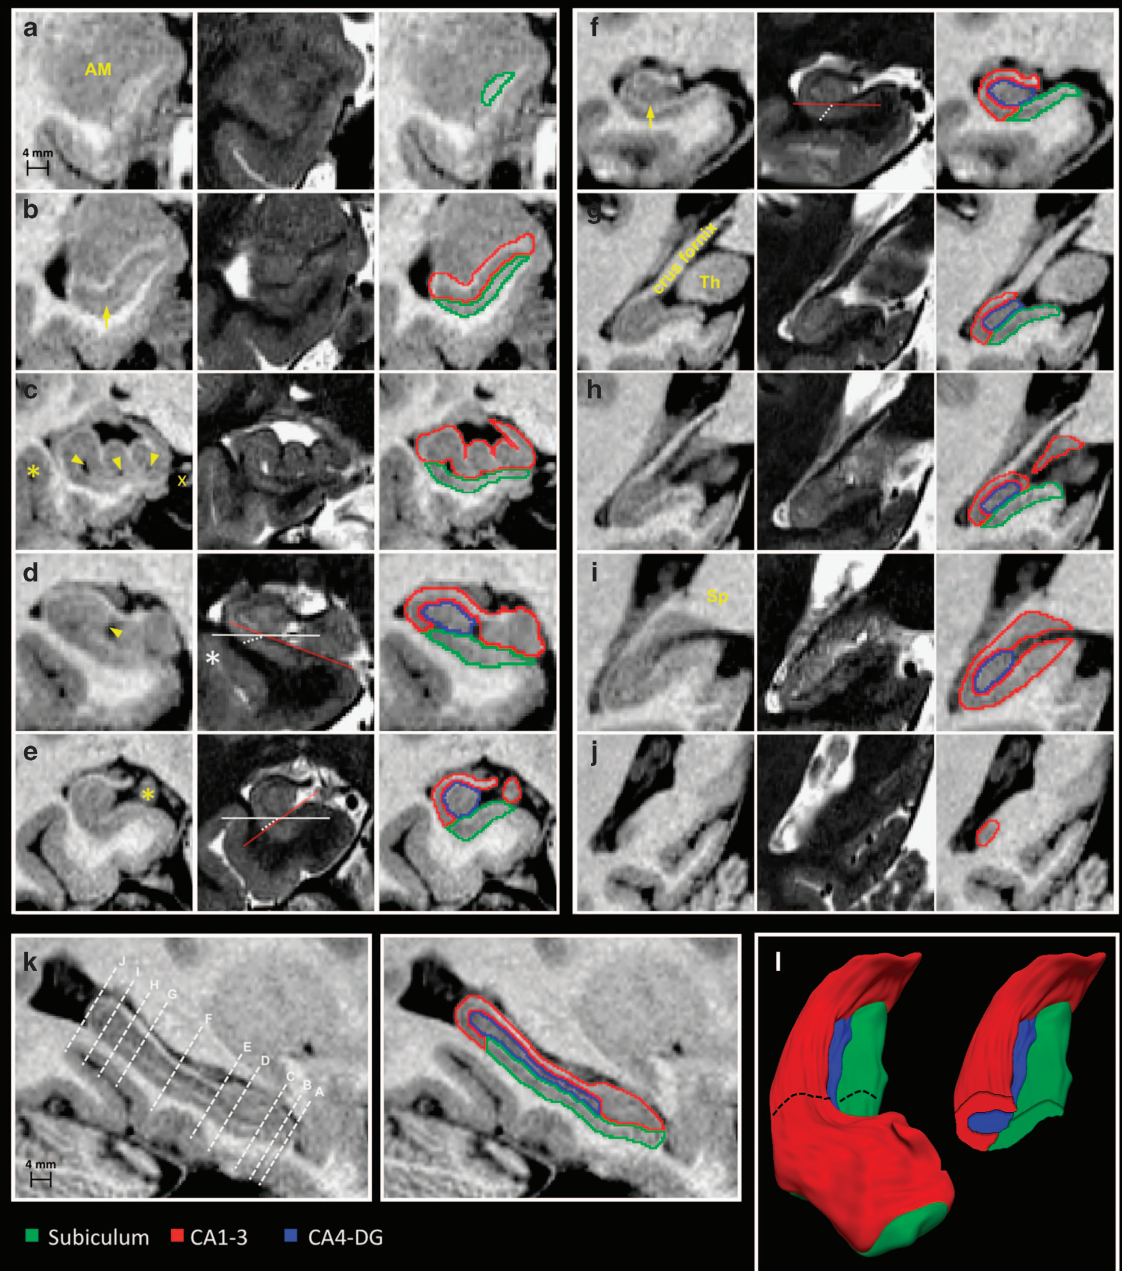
Anatomical boundaries of hippocampal subfields on T1- and T2-weighted MRI. Sections displaying critical landmarks are shown. (a,j) are the most rostral and caudal coronal sections. (a) The rostral-most tip of the hippocampus is composed of the subiculum; at this level, the alveus surrounds the subiculum, separating it from the overlying amygdala (AM). (b) When CA1 first becomes visible, it runs parallel to the subiculum; the structures are separated by the subicular molecular layer (arrow). (c) Vertical digitations of CA1-3 (arrowheads point to cavities within the hippocampal sulcus; x indicates the ambient cistern); the supero-lateral subicular interface with CA1 is drawn along a line following the hippocampal sulcus, directed towards the fundus of the collateral sulcus (asterisk). (d) The rostral-most portion of CA4-DG is set at the section where the medial portion of the DG, the margo denticulatus, becomes visible (arrowhead). (e) Junction between head and body, at the level of the uncus apex (asterisk). (f) Hippocampal body; the arrow points to the molecular layer of the subiculum. (g) Rostral portion of hippocampal tail: the crus fornix is fully visible and well demarcated from the thalamus (Th). (h) The caudal slice of the subiculum is set to the posterior-most section on which the thalamus can be identified. (i) Middle segment of the tail. The subiculum is replaced by CA1-3, at the level at which the crus fornix fuses with the splenium (Sp) of the corpus callosum. (j) Terminal segment of the tail. (k) Sagittal hippocampal section displaying planes of the coronal cuts. (l) 3D surface rendering of hippocampal subfields with a coronal cut at the level of the body. On coronal sections, the orientation of the hippocampal body varies across individuals, modifying the spatial relationships between subiculum and CA1. In d, the hippocampus is oriented clockwise. In e, it is oriented counter-clockwise and in f it has a horizontal position. The red line follows the slope of the superior border of the subiculum, the solid white line represents the horizontal axis, and the dashed white line is placed at the boundary between subiculum and CA1.
